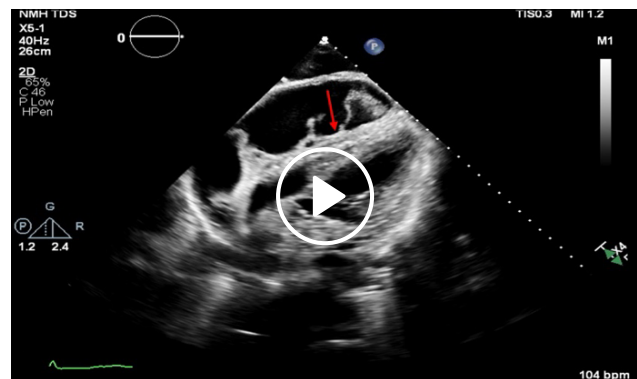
Echocardiographic features of effusive-constrictive pericarditis at presentation. Transthoracic echocardiography demonstrates concurrent features of pericardial effusion, tamponade physiology, and constrictive hemodynamics. (A) Parasternal short-axis view with a large circumferential pericardial effusion containing fibrinous strands (arrow). [Video 1](#) also shows the respirophasic septal shift. (B) Diastolic right ventricular free wall collapse in the subcostal view, consistent with tamponade physiology (arrow; [Video 2](#)). Tissue Doppler imaging reveals annulus reversus, with (C) accentuated medial mitral annular e' velocity (11.1 cm/s) exceeding the (D) lateral e' velocity (8.38 cm/s). The respirophasic septal shift and annulus reversus are suggestive of concomitant constrictive pathophysiology in a patient who has pericardial tamponade.
